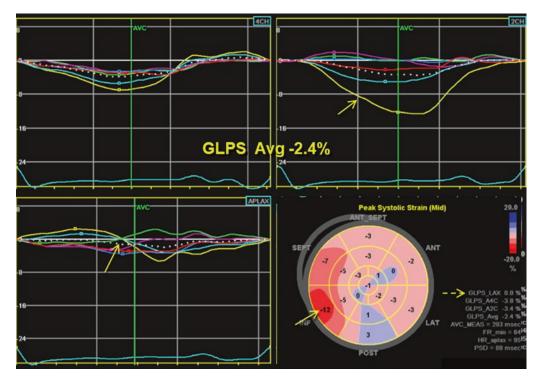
The GLS is reduced in this strain set from a patient with a diffuse ischemic cardiomyopathy. Note the individual view GLS values in the lower right corner. The apical four chamber curves (upper left) have uniform reduced function. The curves in the lower left (apical three chamber view) show a peculiar criss-crossing pattern (arrow) that cancel each other mathematically and render
